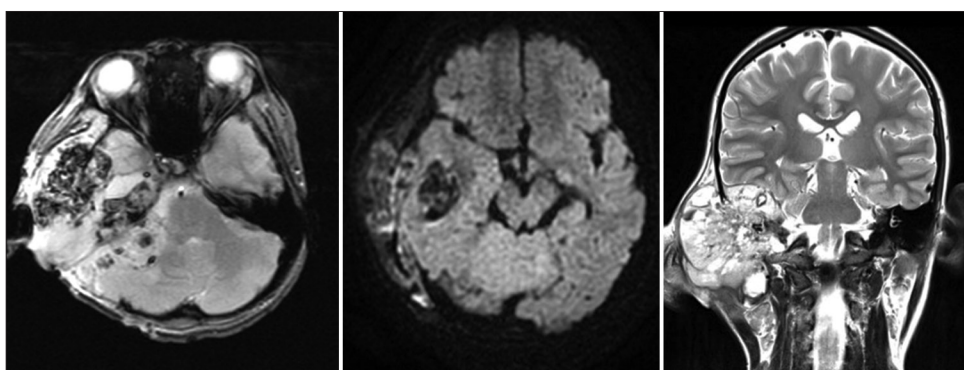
Head magnetic resonance imaging with contrast axial and coronal view, hyperintense with prominent flow voids forming a salt and pepper image on T2-weighted image, unrestricted diffusion in the diffusion-weighted imaging area, which did not show contrast enhancement, a mass was seen destroying the right mastoid, right temporal bone and part of the sphenoid looks intracranial extradural extension.
